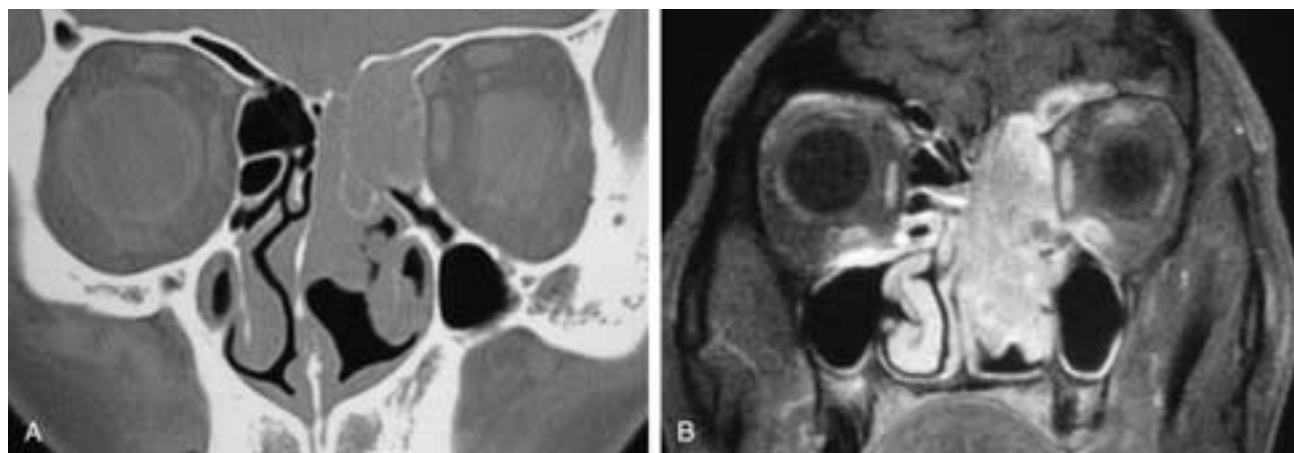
Coronal CT scan (A) shows a mass in the left ethmoid complex and upper nasal fossa. The bone in the region of the left cribriform plate and medial fovea ethmoidalis appears permeated but not completely destroyed. From this image, one might conclude that there is no intracranial disease. However, in B, a coronal T1-weighted, fat-suppressed, contrast-enhanced image, the enhancing tumor is seen to extend along the left floor of the anterior cranial fossa. This patient had a squamous cell carcinoma.
